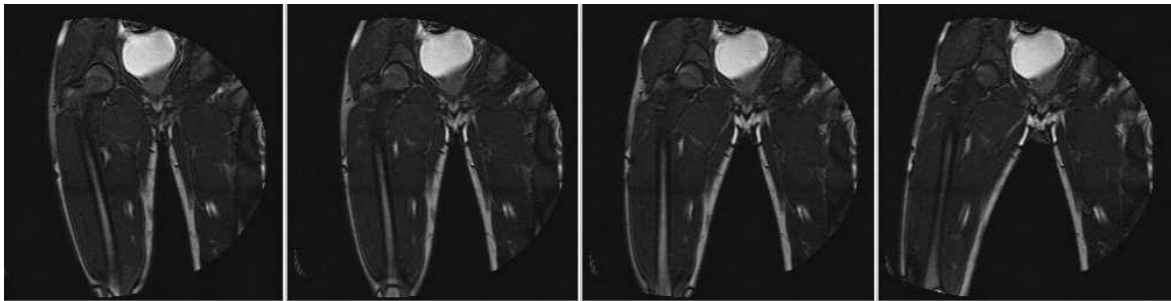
Real-time dynamic MRI of the thigh. Image from [GPMTV04] used by permission.
